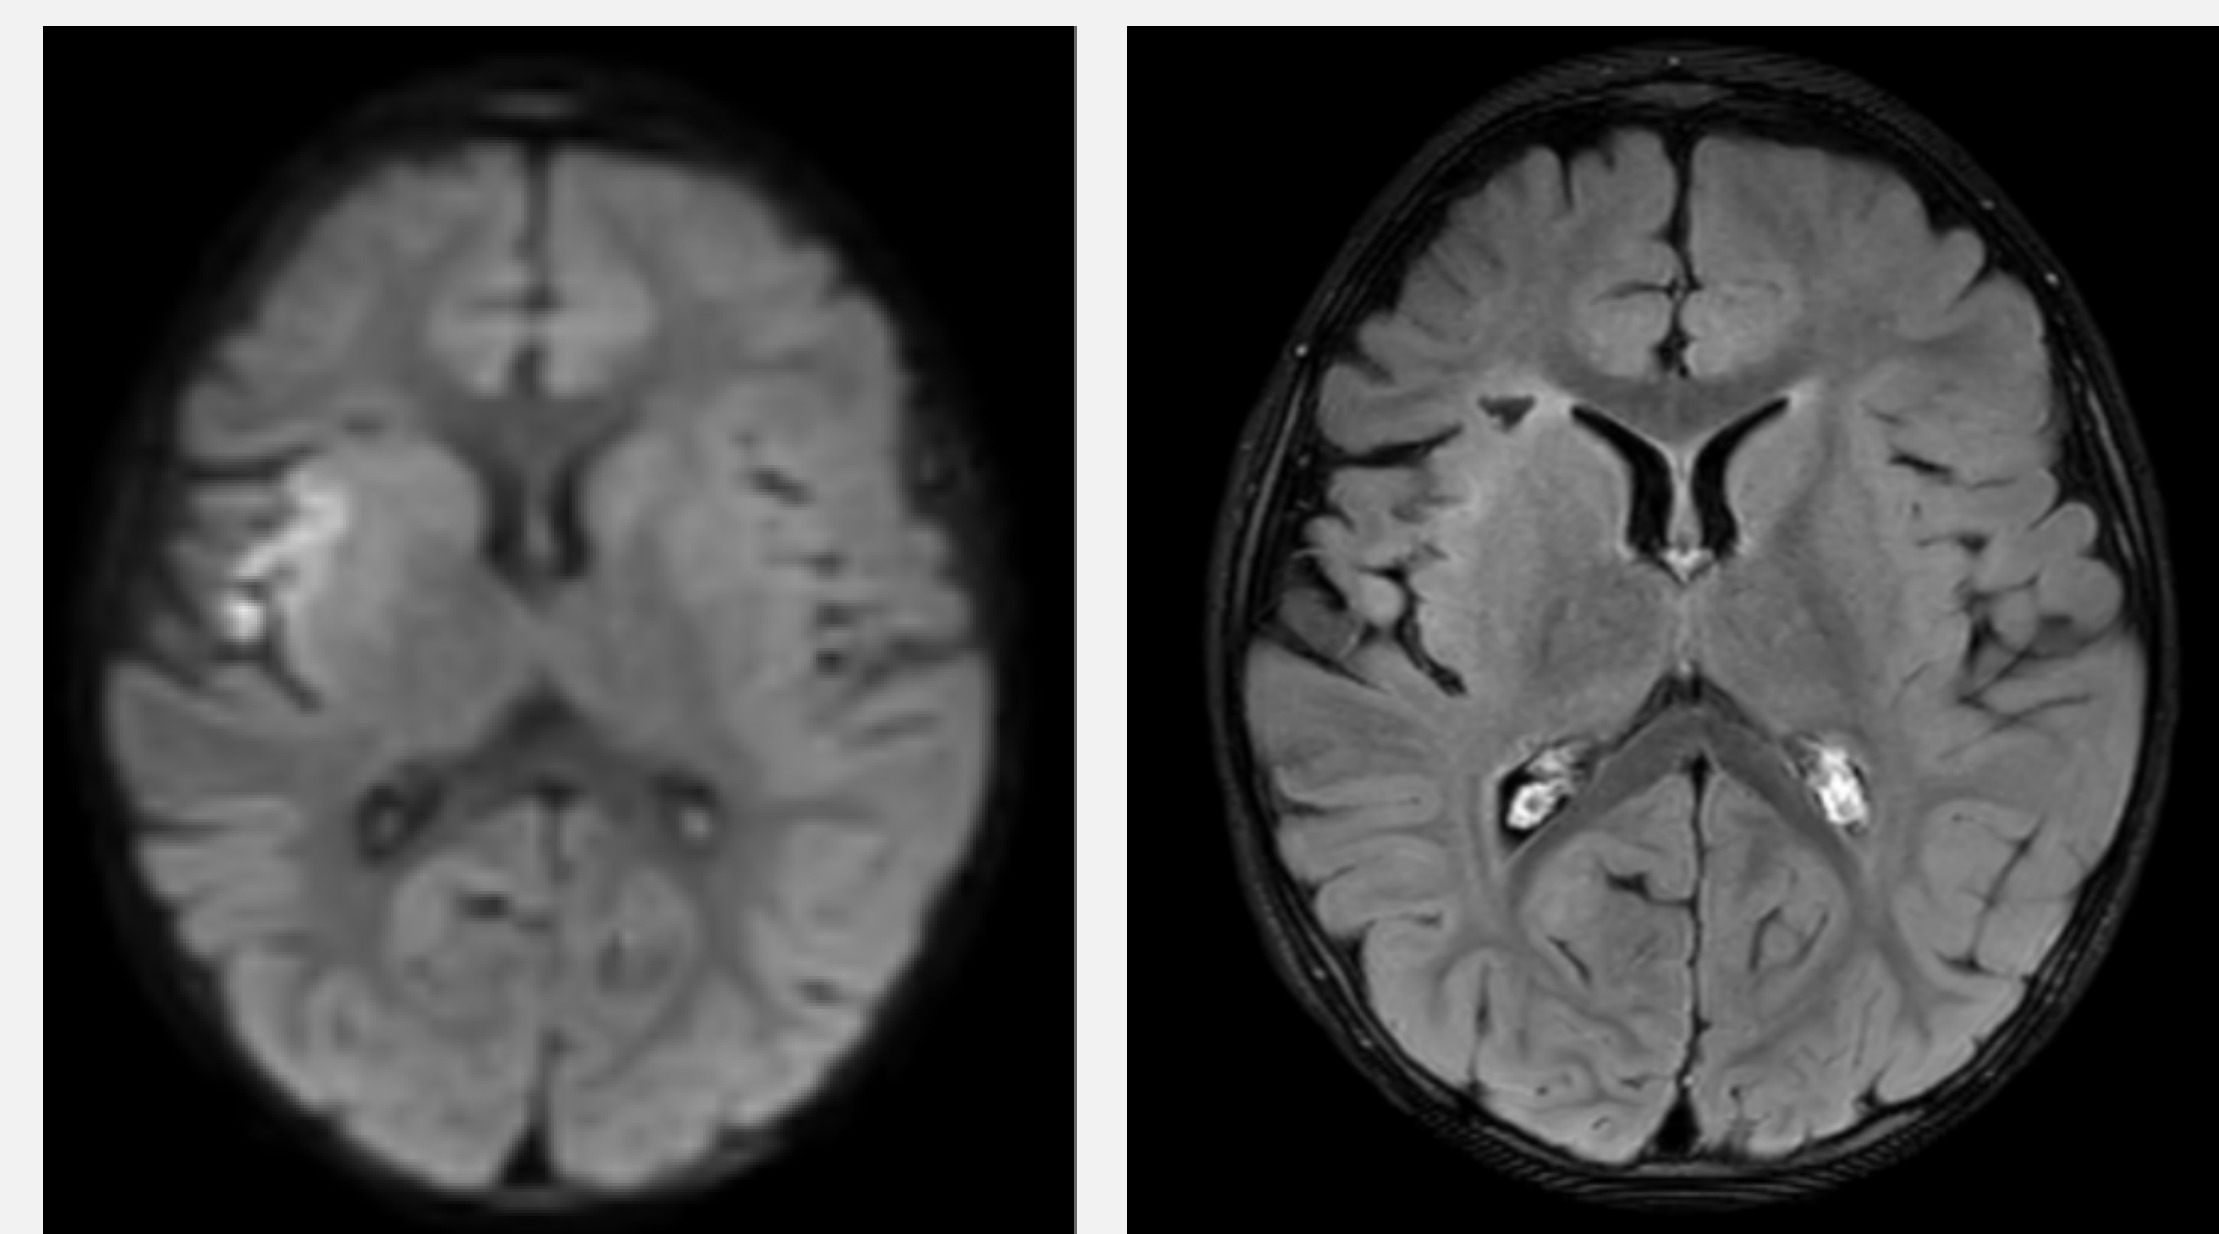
MRI brain with and without contrast on hospital day 2 showing evidence of acute right frontal lobe ischemia as well as right cerebral volume loss and gliosis consistent with chronic ischemia. Axial diffusion restriction (left) and FLAIR (right) sequences shown.
